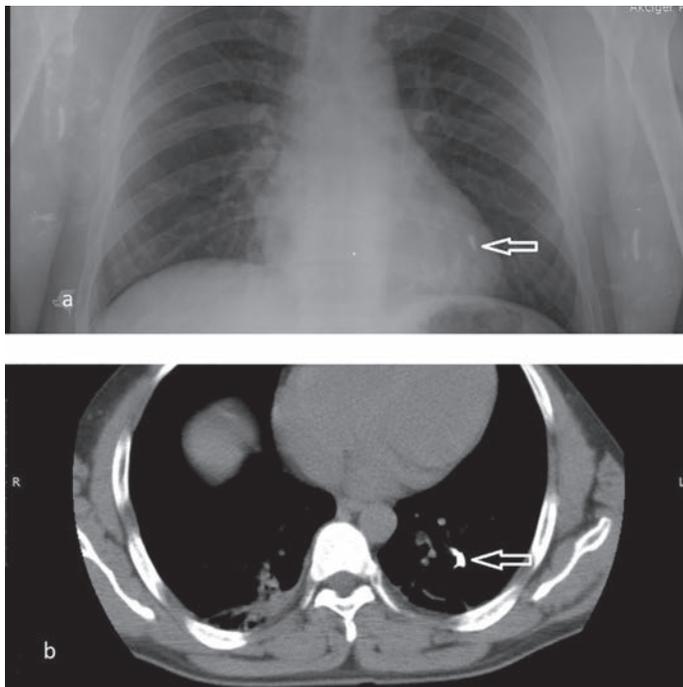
View of the foreign body in the chest: a- Metallic foreign body with smooth, sharp edges on chest radiography of the left lower lobe (white arrow). b- Foreign body in the subsegmental branch of the pulmonary artery on axial CT (white arrow).
